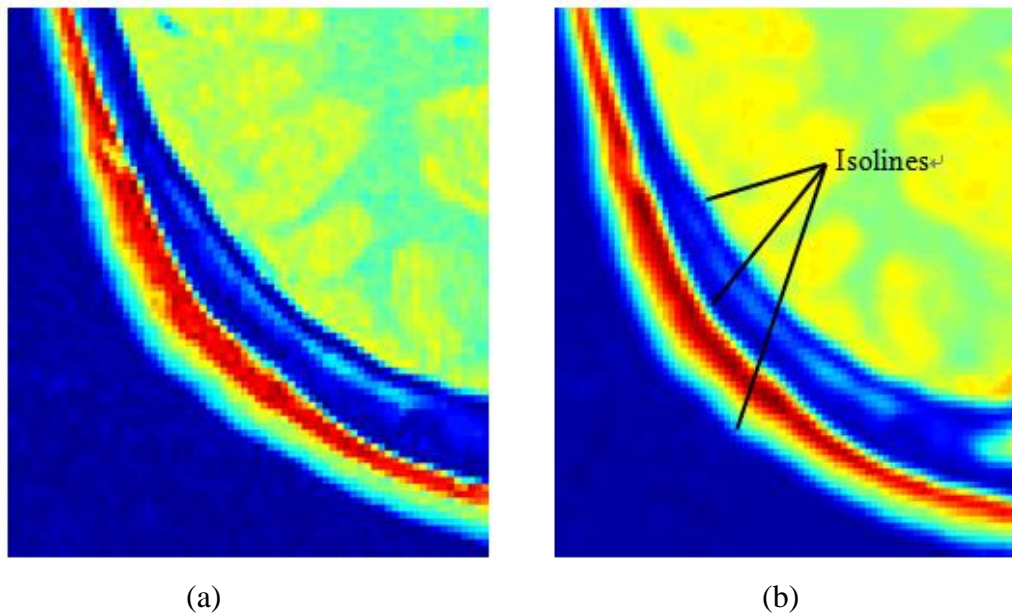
(a) Enhanced MR image; (b) Smoothed MR image
